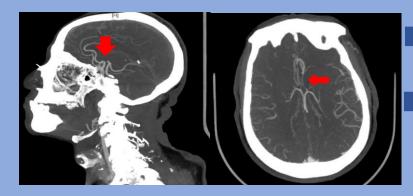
Computed Tomography Angiogram showing acute focal thrombosis of the A2 segment of the left anterior cerebral artery and proximal pericallosal artery.
